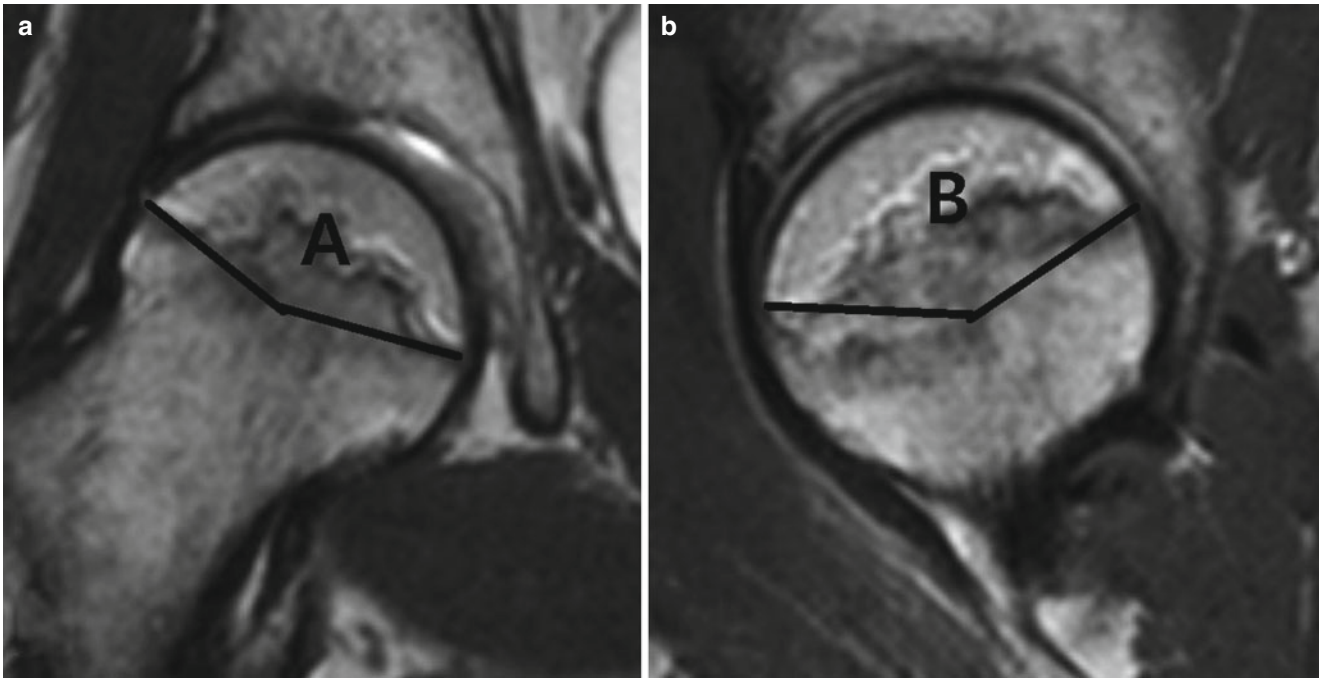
The calculation of the combined necrotic angle from magnetic resonance imaging scans. *A* The angle of necrotic area in the midcoronal image. *B* The angle of necrotic area in the midsagittal image. The combined necrotic angle = $A + B$
